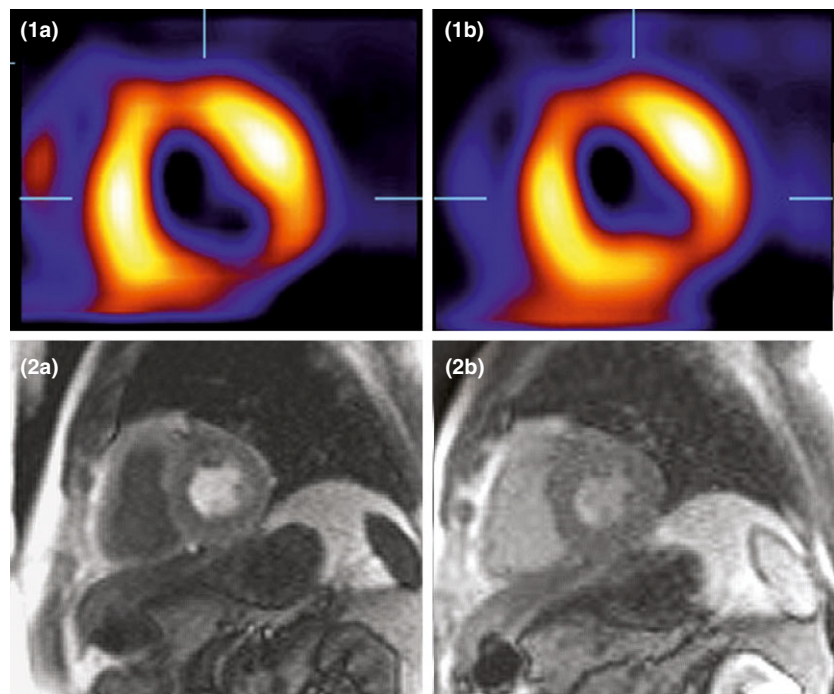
SPECT (1a and 1b) and CMR GRE-EPI (2a and 2b) images of reversible myocardial ischaemia. Stress is 'a' and rest 'b'.
